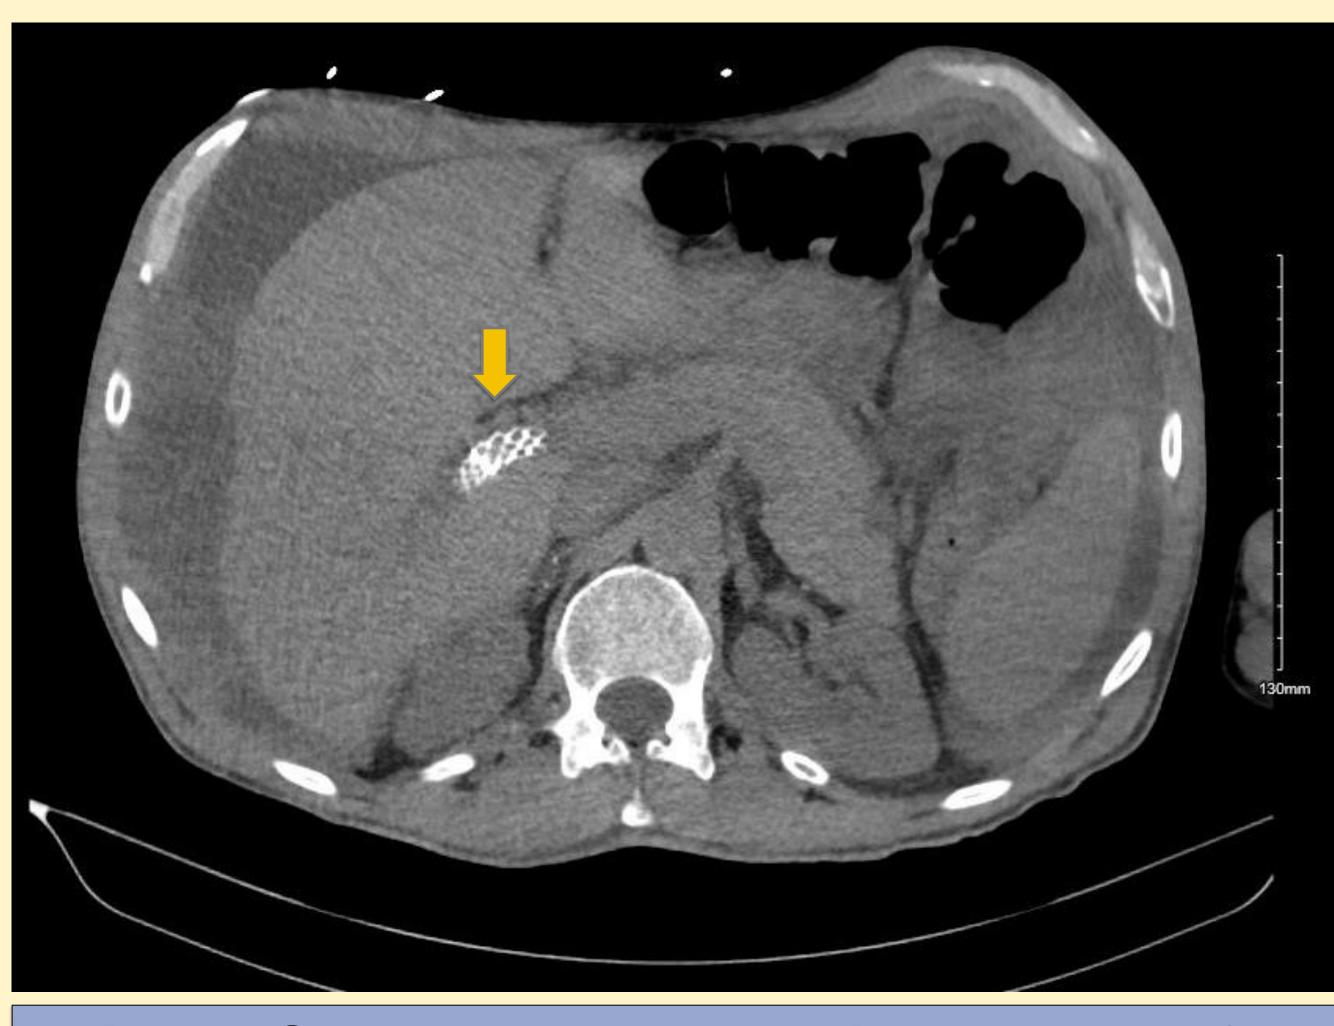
CT Abdomen showing successful placement of TIPS (yellow arrow)
